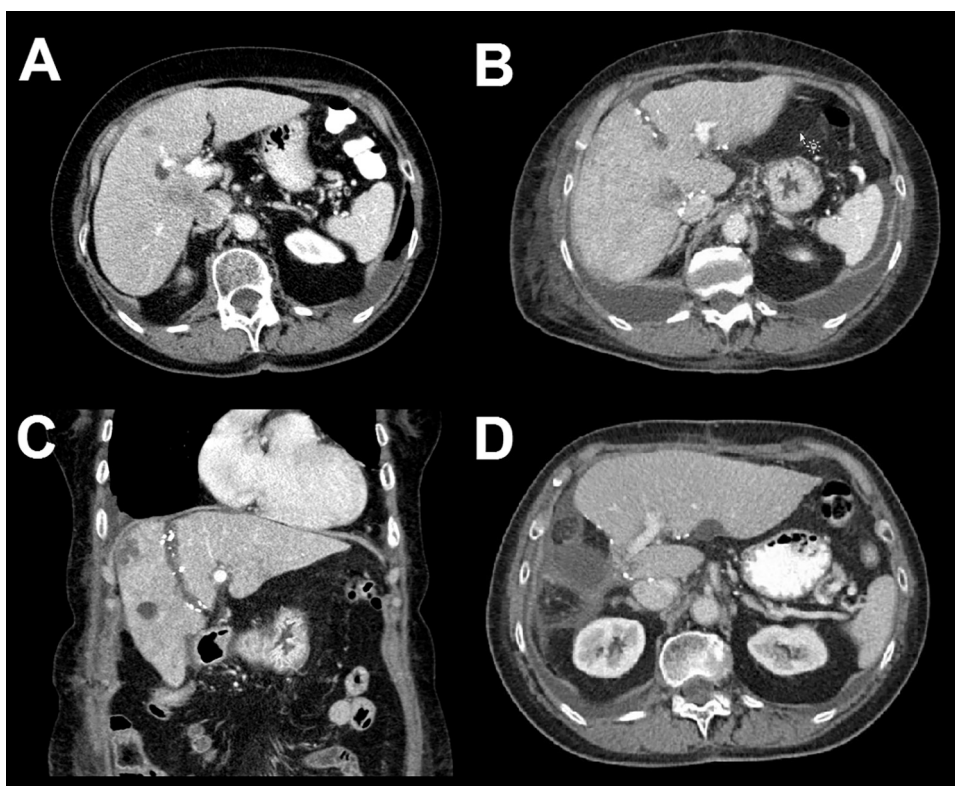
(A) Preoperative CT image with metastases in segments 7 and 8. Intra-operative ultrasound however, identified two additional metastases in segments 8 and 3 necessitating extension of the planned resection. (B) Transverse CT –image after the first stage of ALPPS procedure showing the *in situ* partial transection of the liver according to the planned, extended right hemihepatectomy. The right portal vein has been ligated while the right hepatic artery and right hepatic vein are preserved together with the right bile ducts. (C) Coronal, reconstructed CT image after the first stage of ALPPS demonstrating the split liver. The deportalized right liver lobe shows atrophy while the FRL has markedly hypertrophied. (D) CT image at follow-up after stage-2 demonstrating the completed right hemihepatectomy with the hypertrophied remnant liver.
